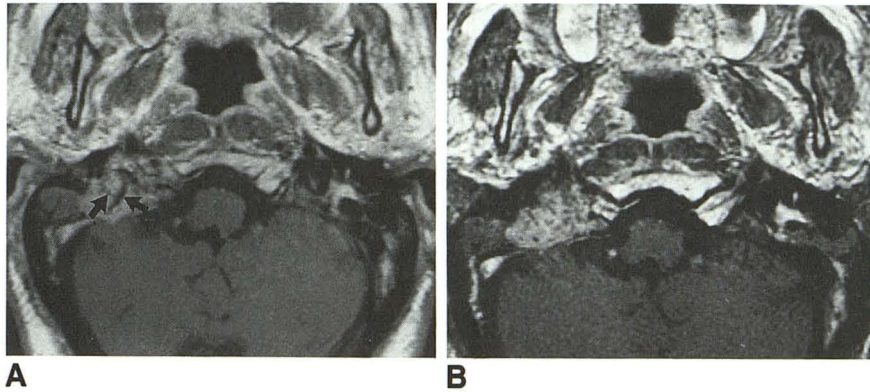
Enhanced axial T1-weighted images.
